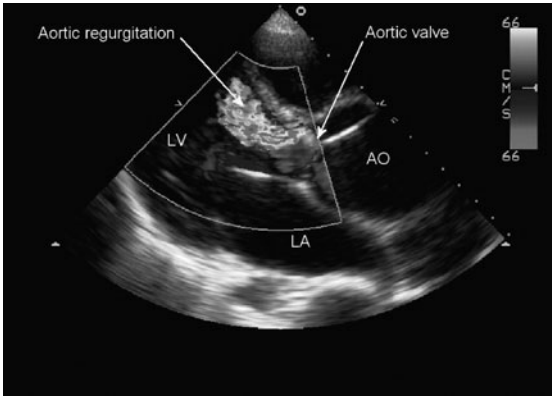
Parasternal transthoracic echocardiogram demonstrating a broad jet of AR in a patient with a dilated aorta (AO).
